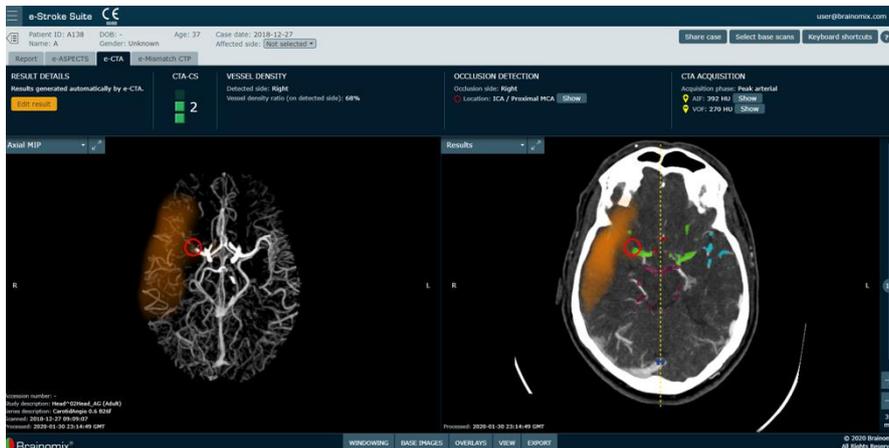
An example of e-CTA output on the web user interface, highlighting the presence of a large vessel occlusion and quantifying the extent of collateral blood vessels.
